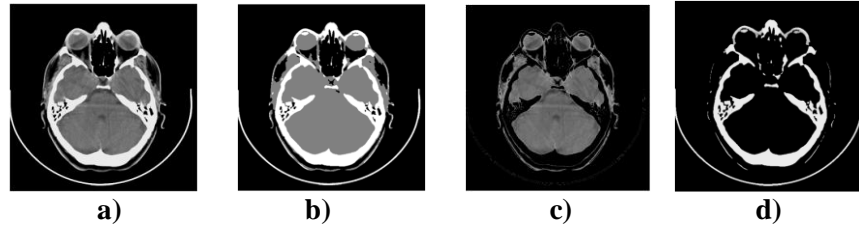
9 k-means algorithm applied on CT slice (2 classes in this case)
